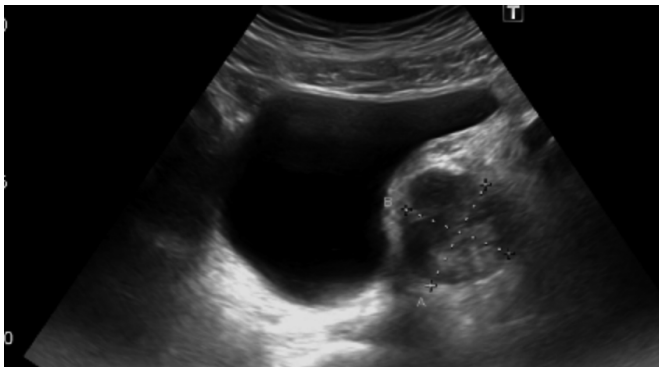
Pelvic ultrasound shows a solid mass adjacent to the bladder wall. An echogenic fat plane was seen between these two structures.
